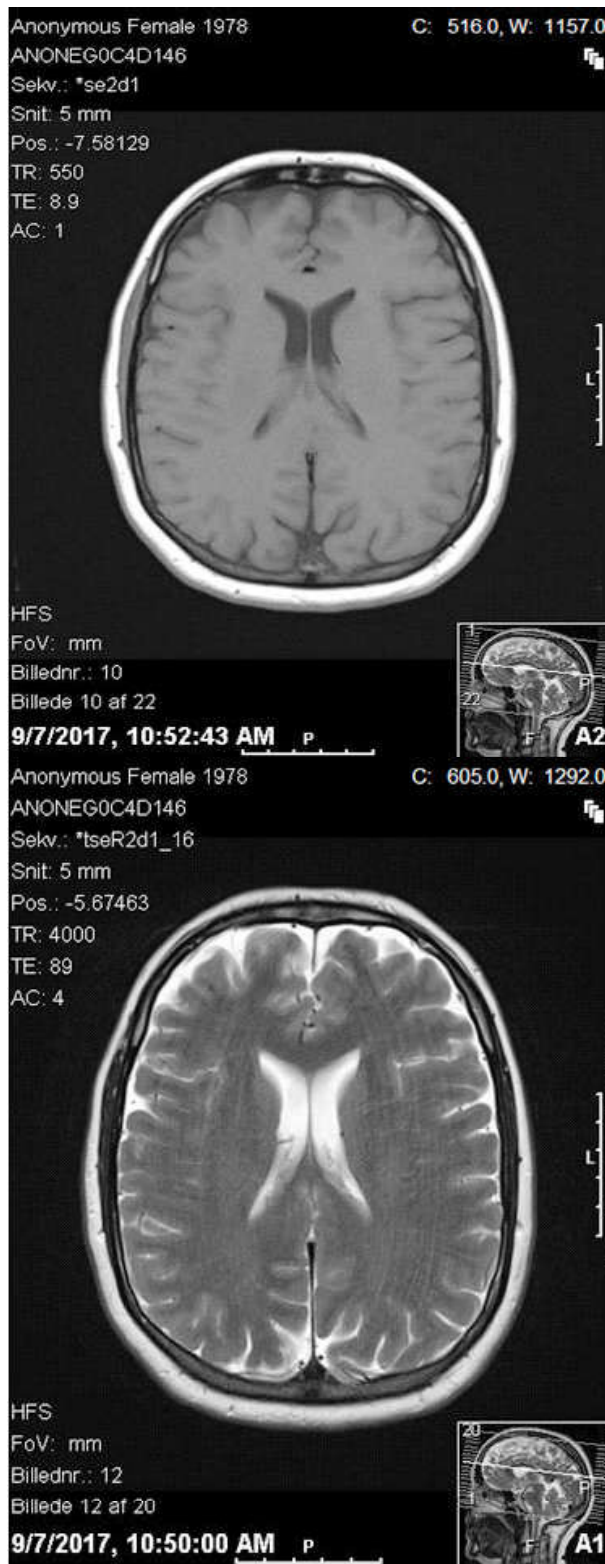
MRI scan of the brain showing signs of ischaemic changes in the cortex and in basal ganglia
